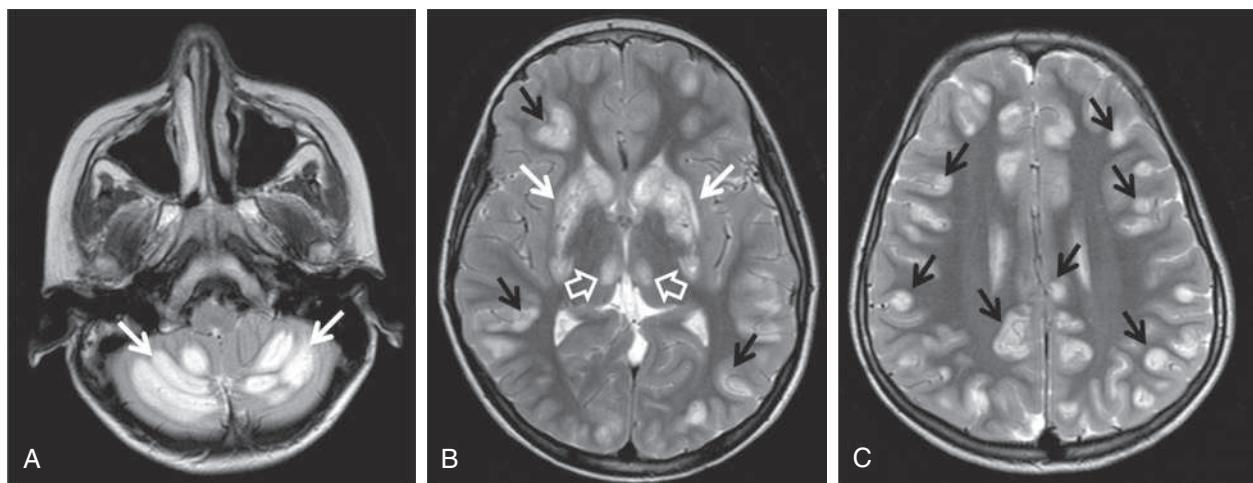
Biotin-responsive basal ganglia disease. An initial brain MRI showed high signal intensity alterations on T2-weighted images bilaterally involving the (A) cerebellum (arrows), (B) basal ganglia (white arrows), and medial nucleus of the thalamus (open arrow) and (B, C) cerebral cortex (black arrows). (Modified from Tabarki B, Al-Sheikh F, Al-Shahwan S, Zuccoli G. Bilateral external ophthalmoplegia in biotin-responsive basal ganglia disease. *J Pediatr.* 2013;162:1291–1292.)
